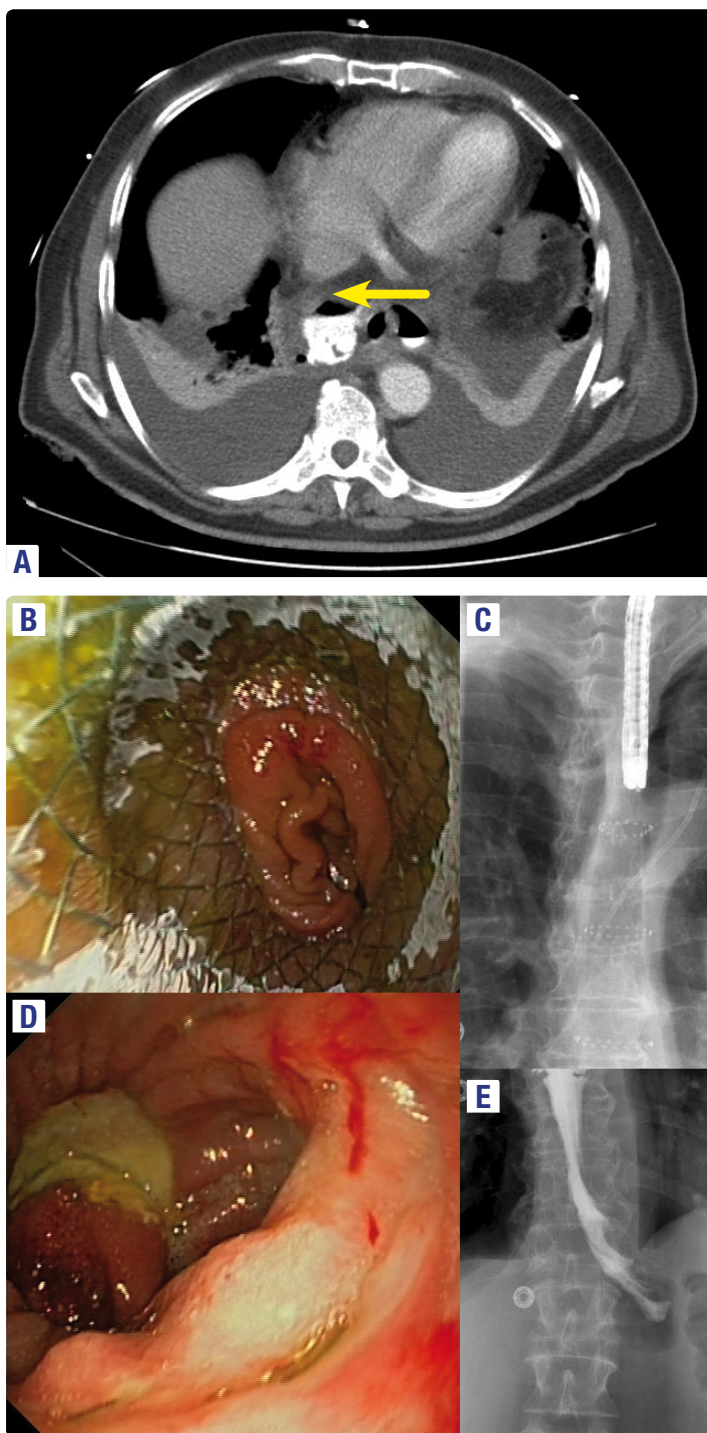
A: CT scan showing an acute EJAL. B,C: Stent deployment and radiological control. D,E: Leak sealed after stent retrieval and transit with oral contrast without extravasation.
